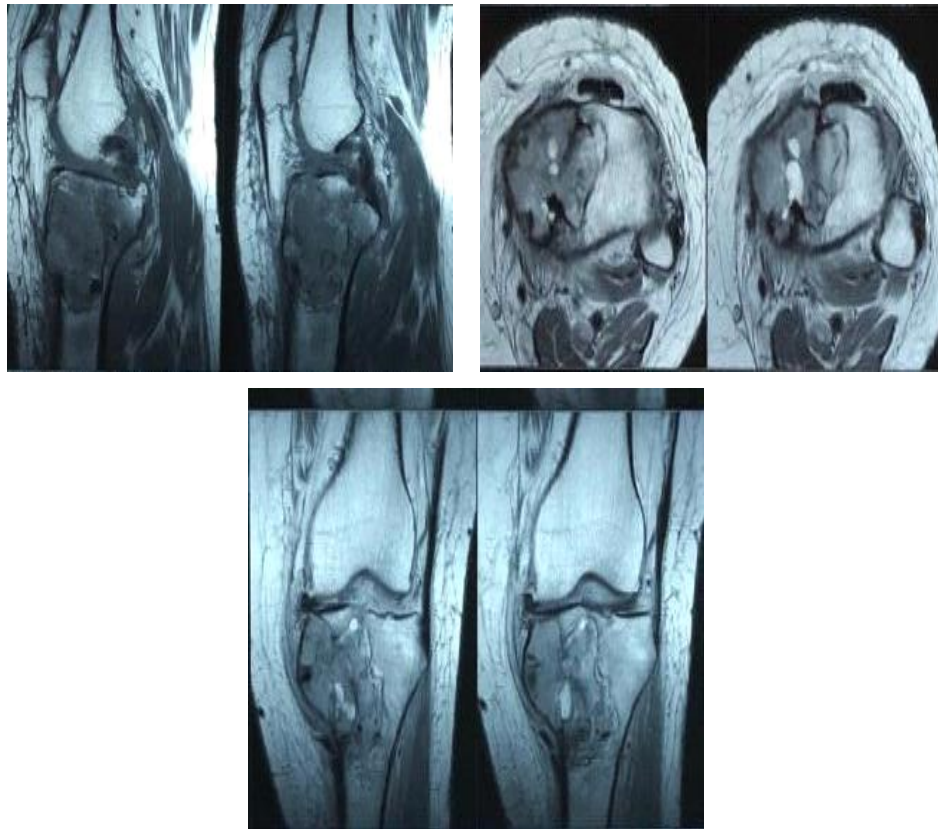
Sagittal, Coronal and Axial slices of MRI showing the well-defined, lytic, expansile lesion in the left proximal tibia involving the medial condyle without cortical break
